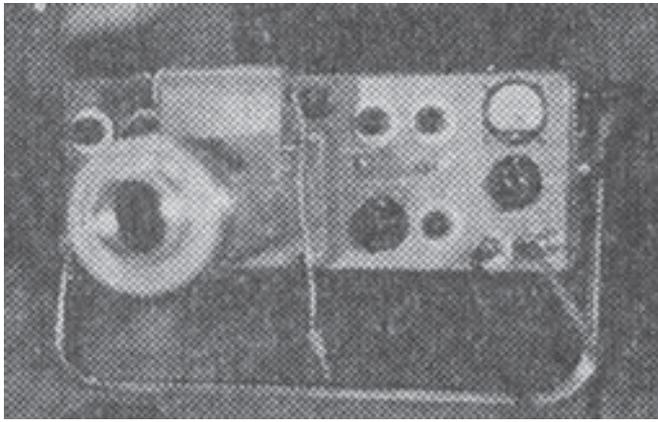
Clinical ultrasound A-mode device
